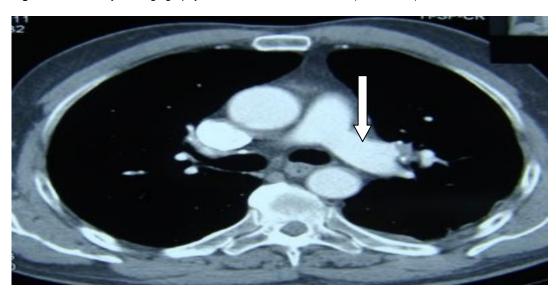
Pulmonary CT angiography shows intra-arterial clot in left (white arrow)
